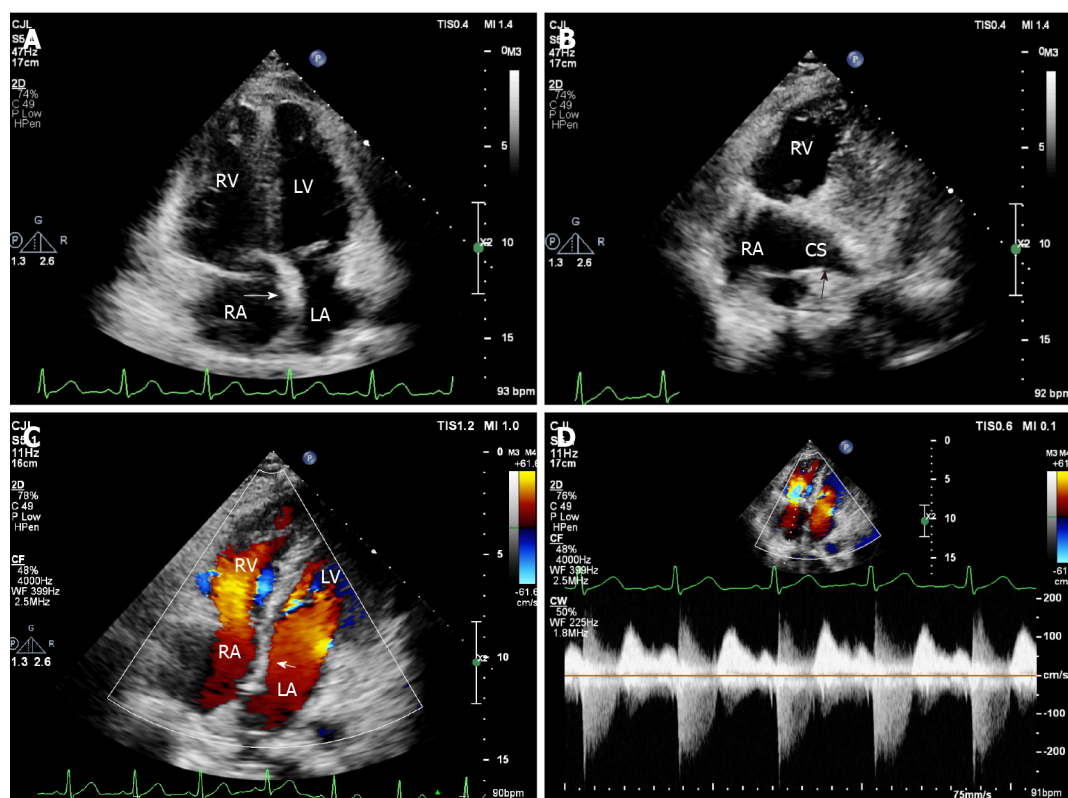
Transthoracic echocardiography at 1 wk after surgery. A: The repaired atrial septum was continuous and complete on apical four-chamber view (arrow); B: The repaired coronary sinus (CS) roof was continuous and complete on apical four-chamber view (arrow); C: There was no shunt from the left atrium to right atrium on apical four-chamber view (arrow); D: Trace tricuspid regurgitation ($V_{\max} = 223$ cm/s, pressure gradient = 20 mmHg, pulmonary artery systolic pressure = 25 mmHg). RA: Right atrium; RV: Right ventricle; LA: Left atrium; LV: Left ventricle; CS: Coronary sinus.
